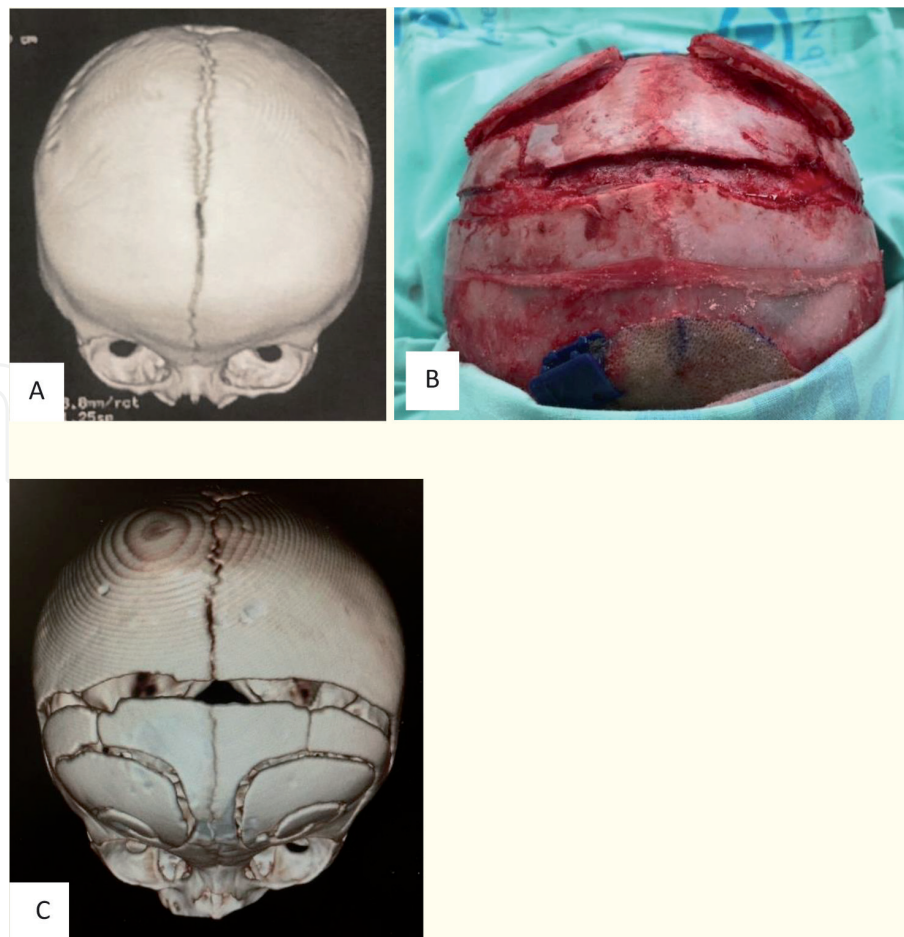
Anterior brachycephaly. (A) Pre- surgical 3-D computerized tomography (CT) (B) Intraoperative view of osteotomies for coronal suturectomy and bilateral spiral osteotomies (C) Post-surgical 3-D computerized tomography (CT) superior view.
